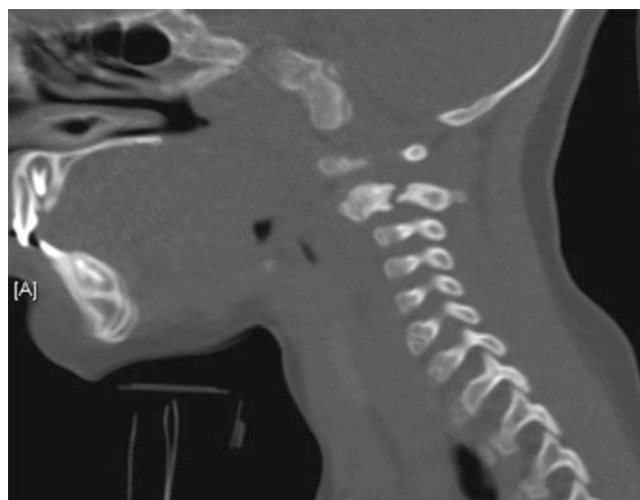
Helical CT scan reconstruction of C2 “hangman’s” fracture in a 1-year-old
